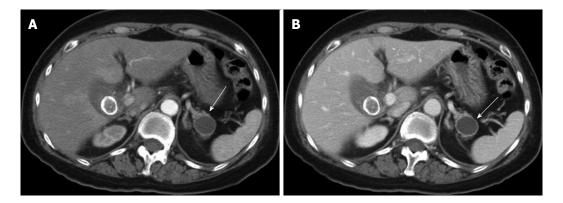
Computed tomography imaging of the abdomen the first time. The arterial phase (A) and portal venous phase (B) revealed a 2.2 cm × 2.0 cm well-circumscribed cystic lesion that was located at the pancreatic tail with a peripheral enhancing thick cystic wall that surrounded a non-enhancing low-attenuation area consistent with cystic fluid. We diagnosed it as mucinous cystadenoma.
